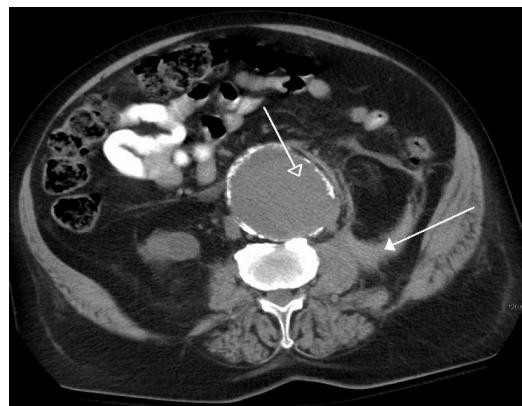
CT image of Ruptured AAA
